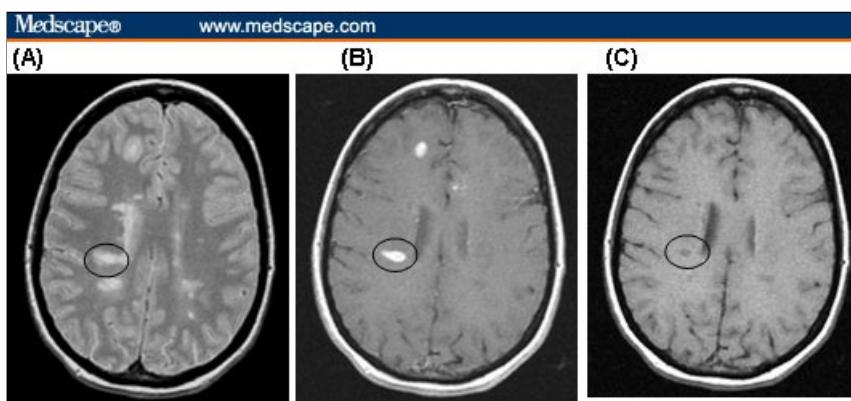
MS lesions on conventional MRI. Circled is an active lesion, showing (A) hyperintensity on T2-weighted images; (B) hyperintensity on postgadolinium T1-weighted images; and (C) hypointensity on T1-weighted images without gadolinium.
